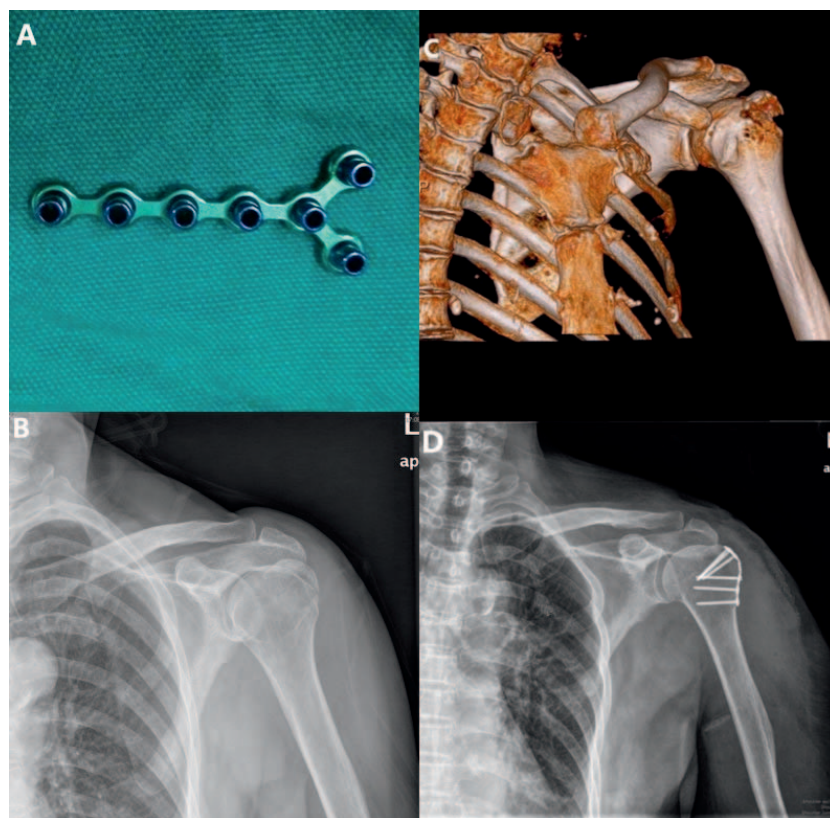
(A) An F3 Biomet plate. (B) An anteroposterior X-ray of a displaced greater tuberosity fracture of the left shoulder in a 61-year-old woman who sustained a fall injury. (C) Preoperative computed tomography 3-dimensional reconstruction. (D) An anteroposterior X-ray taken after the implantation of F3 Biomet plates 1 year after the surgery.
